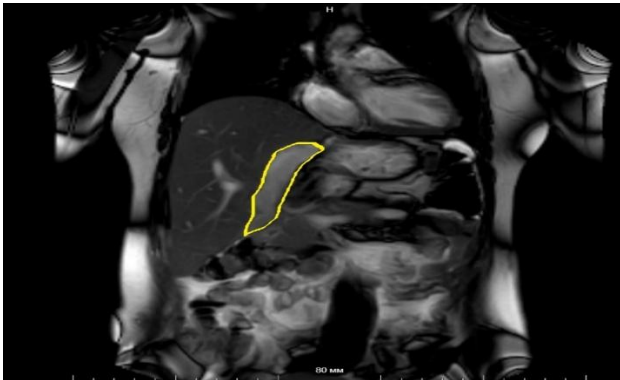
MRI-scan shows the abscess in surgical site.
